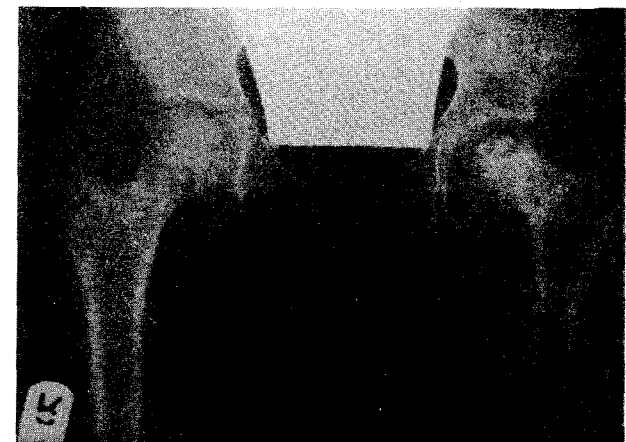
X-ray of the patient one year and four months after trauma (a) immediately before implants removal, and (b) immediately after removal of implants. Avascular necrosis with varus deformity are obvious on the left side.
